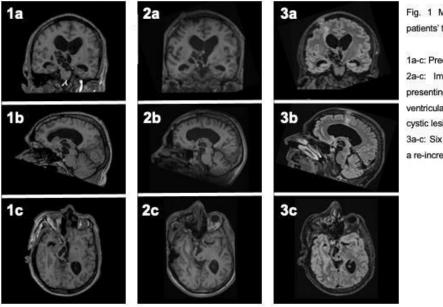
MRI of the GTPVS during the patients' treatment
